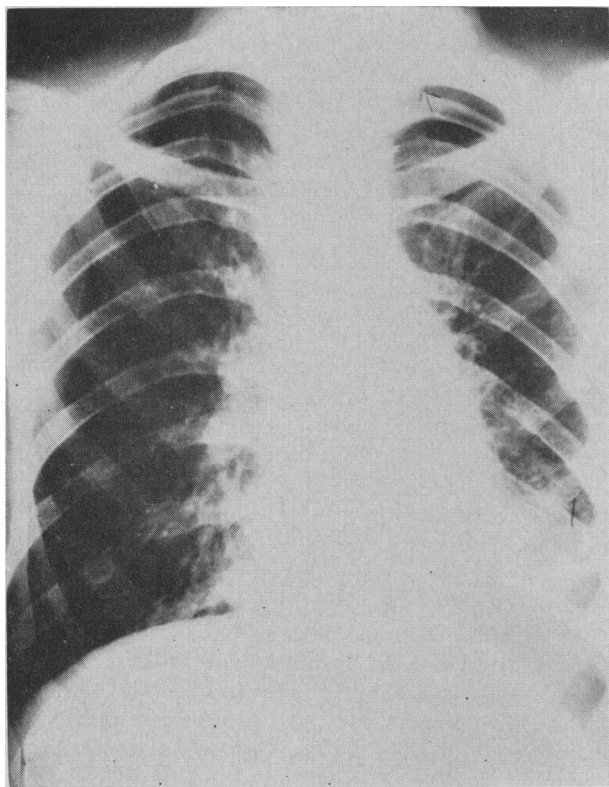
Radiograph of chest after radiotherapy was administered, showing only residual involvement of the left lower lobe.
